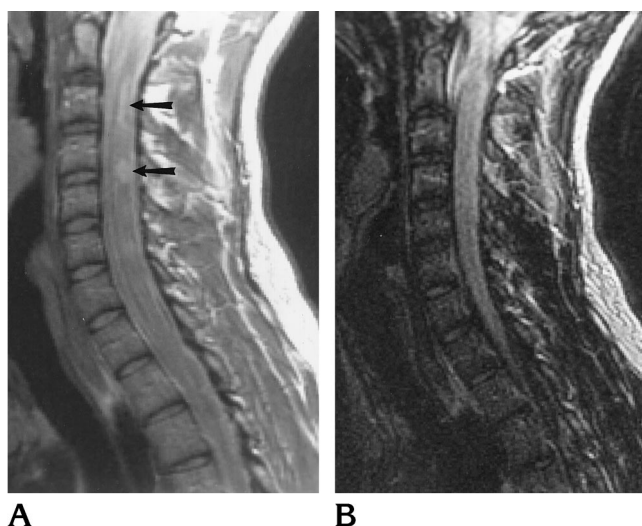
A 29-year old man with known cervical spinal cord MS lesions. Sagittal 3-mm fast spin-echo (2883/17/1) (A) and fast FLAIR (6000/150/1, TI of 2000) (B) images. Proton density-weighted image clearly shows two MS lesions of the cervical cord (arrows) that are not seen at all on the short-TR/TE FLAIR image.
